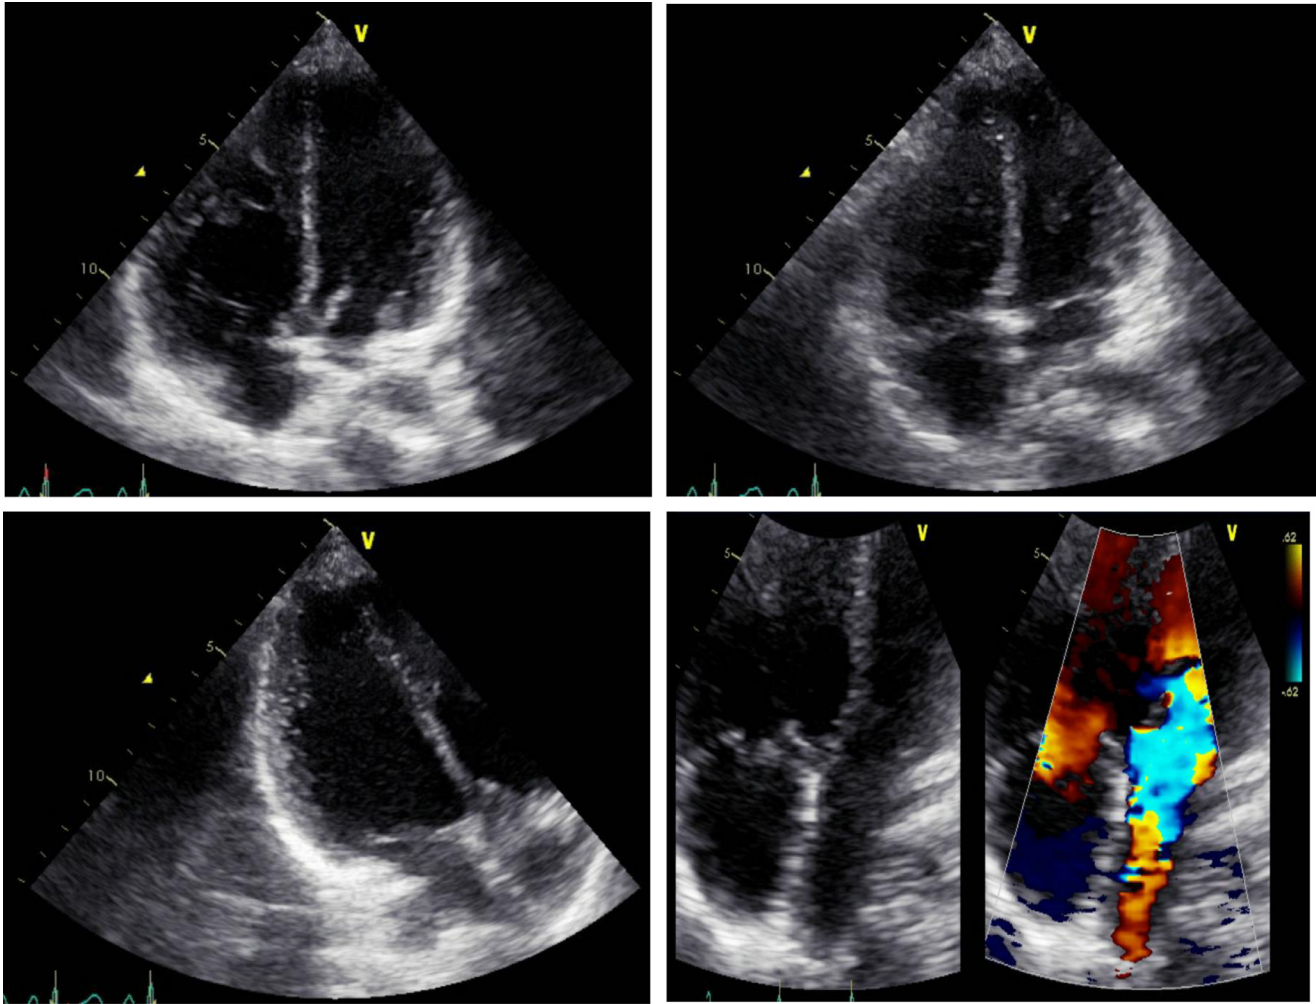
Grayscale and color-Doppler Transthoracic echocardiogram show hyper-trabeculated right ventricle with normal wall-thickness, moderately to severely dilated right ventricle. The right ventricular systolic pressure (RVSP) was 100-105 mmHg with flattening of interventricular septum, suggestive of right ventricular pressure/volume overload. The right atrium was mildly to moderately dilated and there was mild to moderate tricuspid regurgitation.
